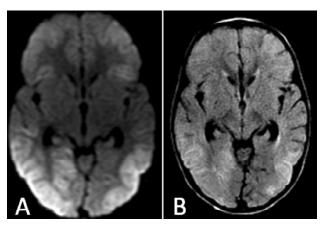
A 44-year-old male had respiratory failure following oesophageal perforation. He underwent an MRI scan: (A) diffusion-weighted image shows high signal intensity areas along the frontal, temporal-parietal and occipital cortices, and the hippocampi bilaterally. Extensive bilateral hemispheric cortical oedema more in the occipital lobes is seen on the axial fluid-attenuated inversion – recovery (FLAIR) image (B).
